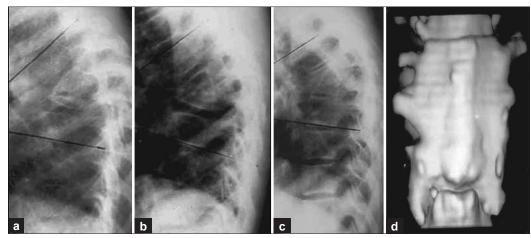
(a) Preoperative X-ray of dorsal spine (lateral view) with tubercular lesion and kyphosis: Angle of 40° (case No. 5 (5 years old male) with progressive kyphosis over two years followup prior to surgery). (b) followup X-ray: 1.6 years after posterior fusion. (c) followup X-ray: 3.6 years after posterior fusion: angle of 30°. (d) CT scan showing excellent fusion mass at contiguous three levels
